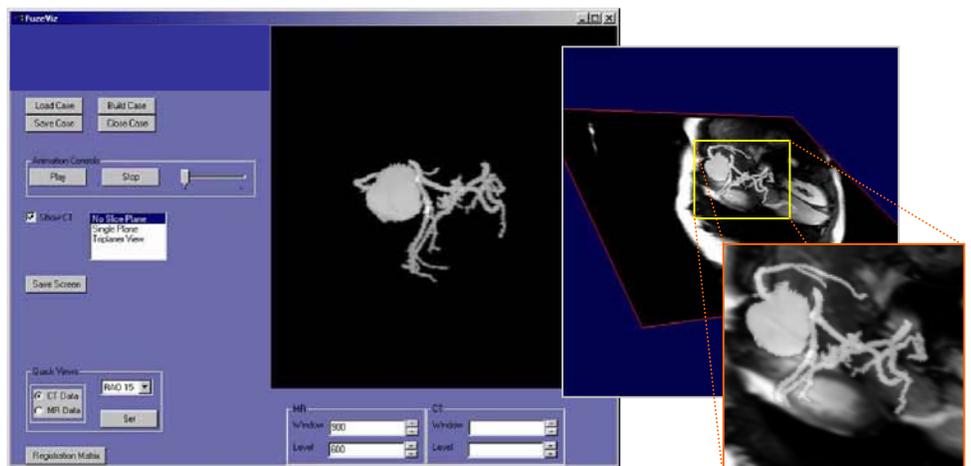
FuseViz: VTK Based interactive environment to visualize Cardiac MR & CTA Data. MIP View of CTA with MR MPR underlay (enlarged)
